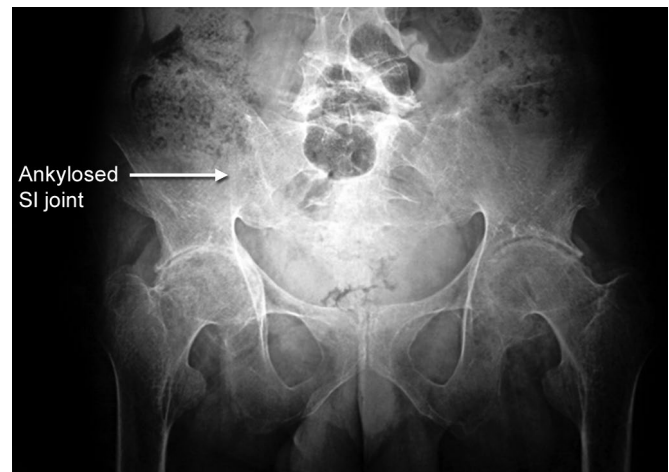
X-ray pelvis anteroposterior view showing sacroiliac joint ankylosis in ankylosing spondylitis.
